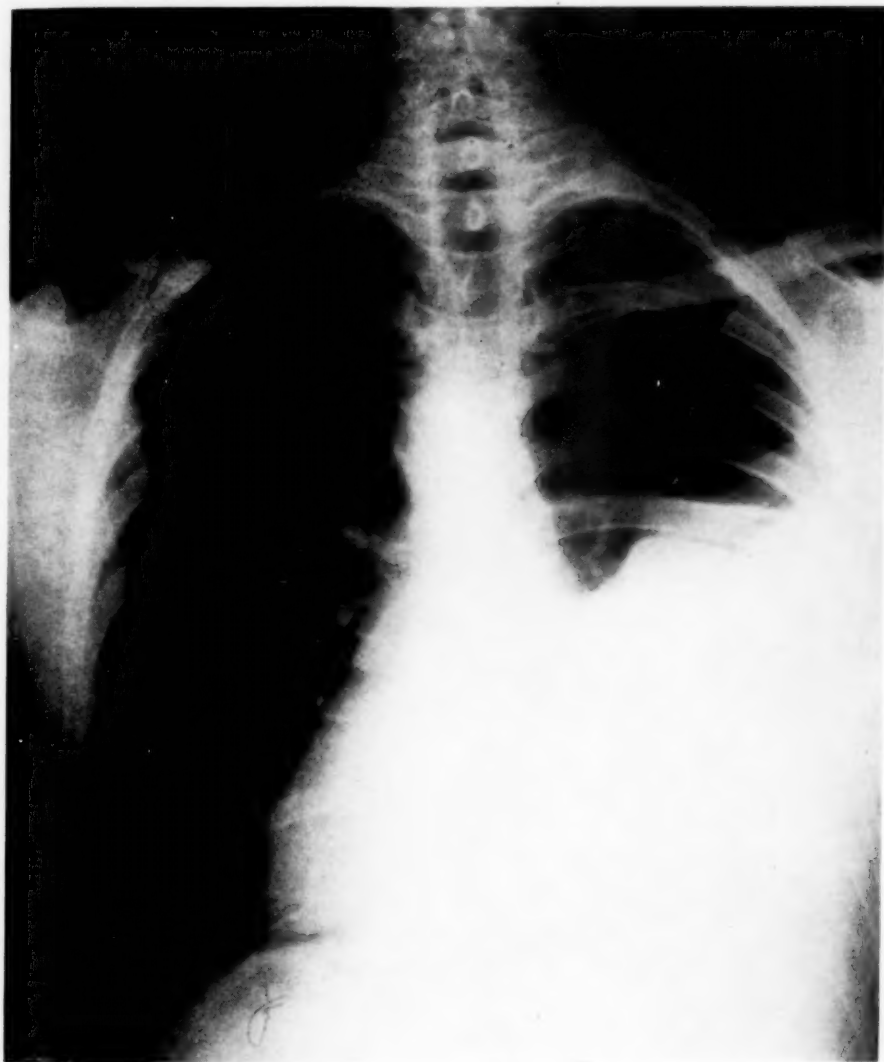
Admission roentgen-ray showing chylous effusion on the right side.
